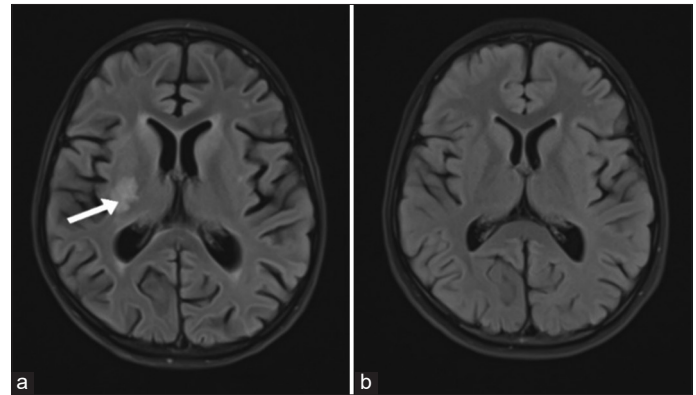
MRI brain, axial T2/FLAIR image showing asymmetrical abnormal areas of hyperintense signal in right basal ganglia (a-White arrow); Follow up MRI brain showing almost complete resolution of previously noted abnormal T2/FLAIR hyperintense signal (b)
